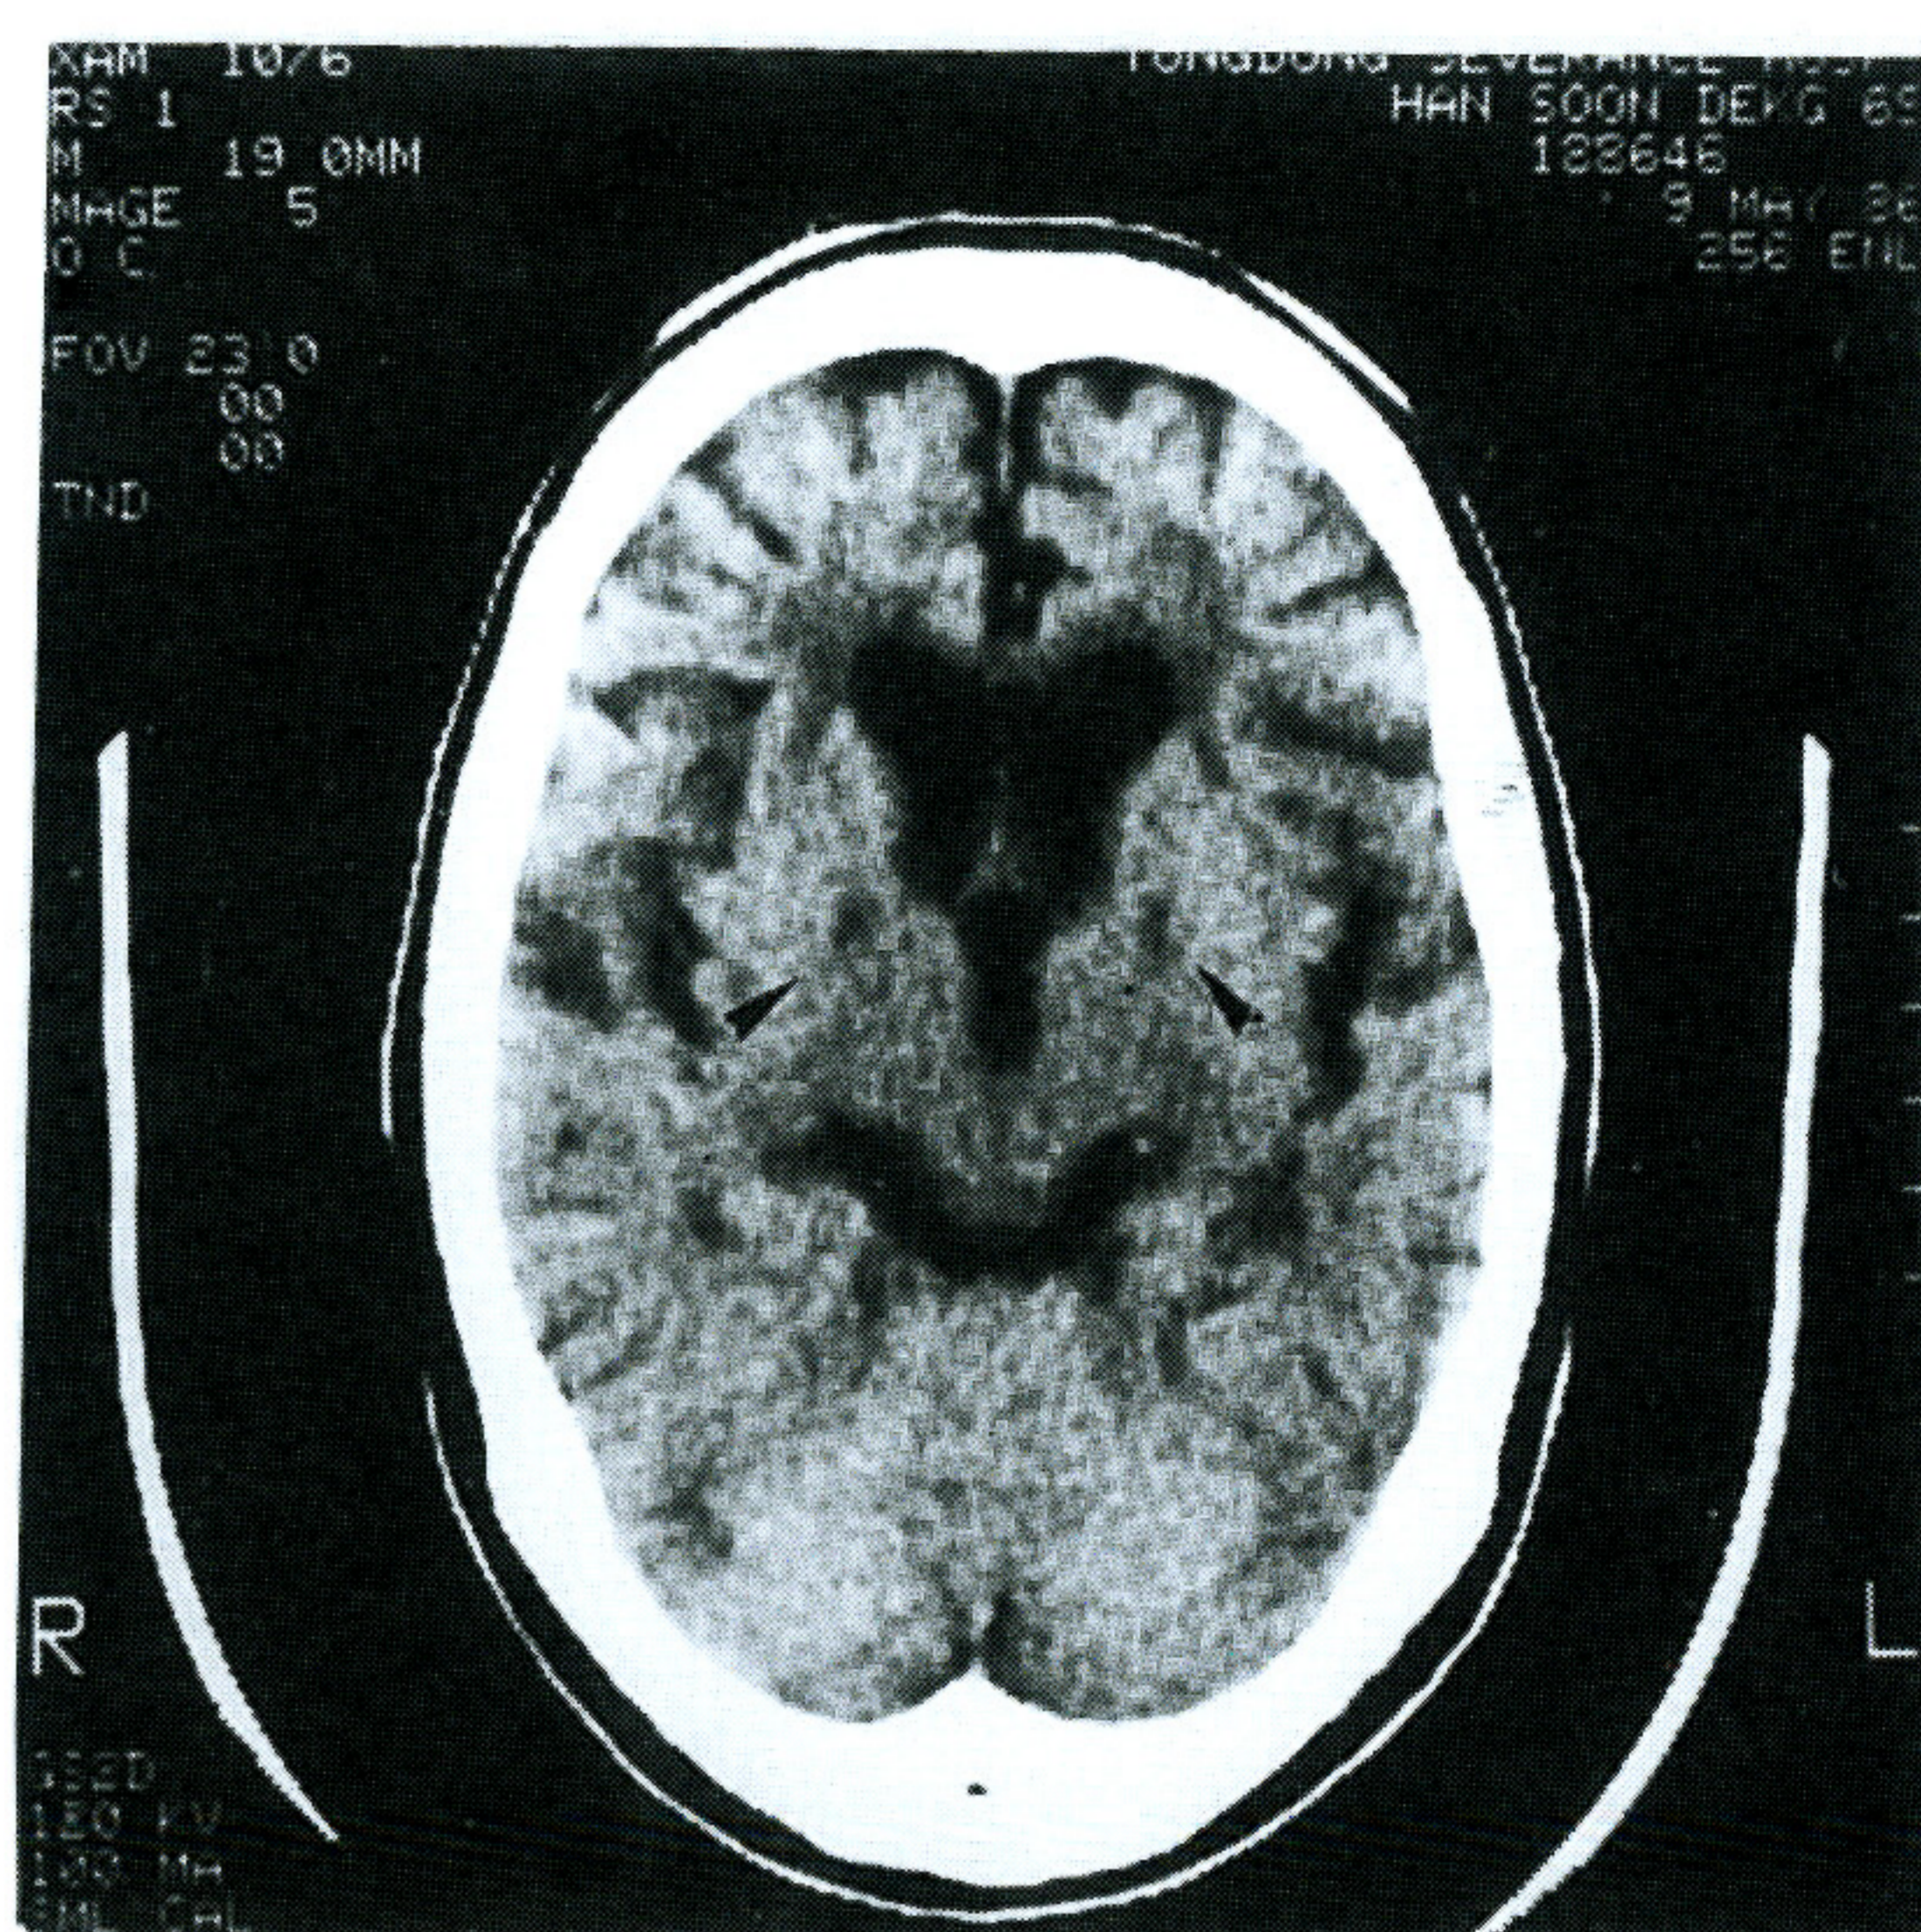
CT scan 26 months after anoxia still showed low-density in both globus pallidi with cortical atrophy.
